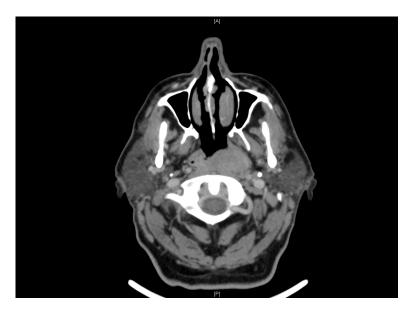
CT scan: Infiltrative soft tissue mass arising from the left fossa of Rosen Muller with bilateral retropharyngeal lymphadenopathy
